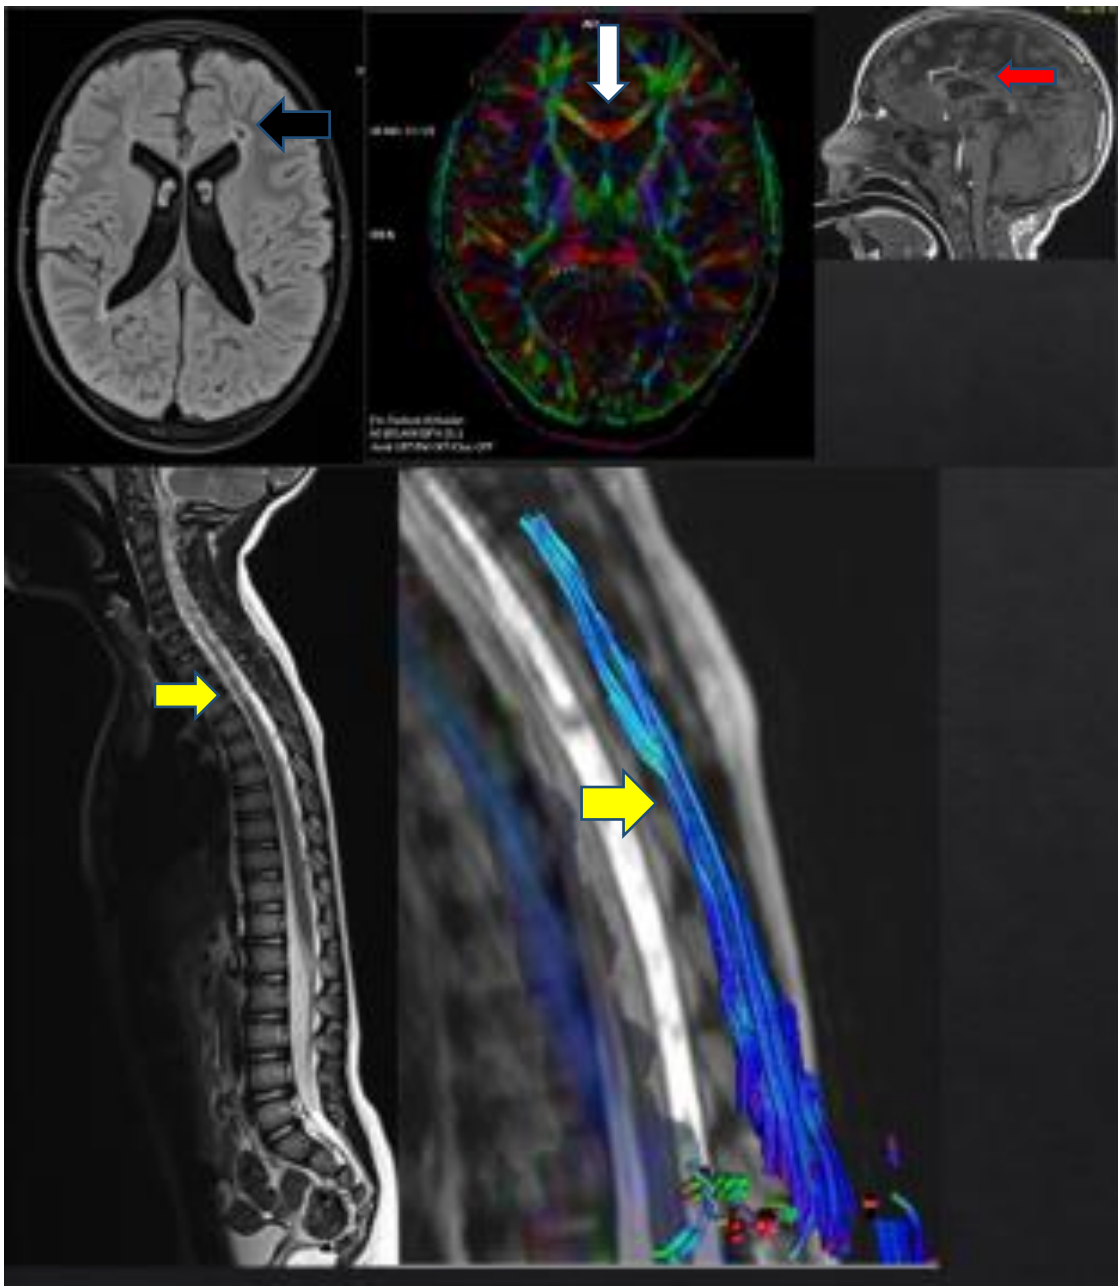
MRI with tractography of brain and spinal cord of patient V.
